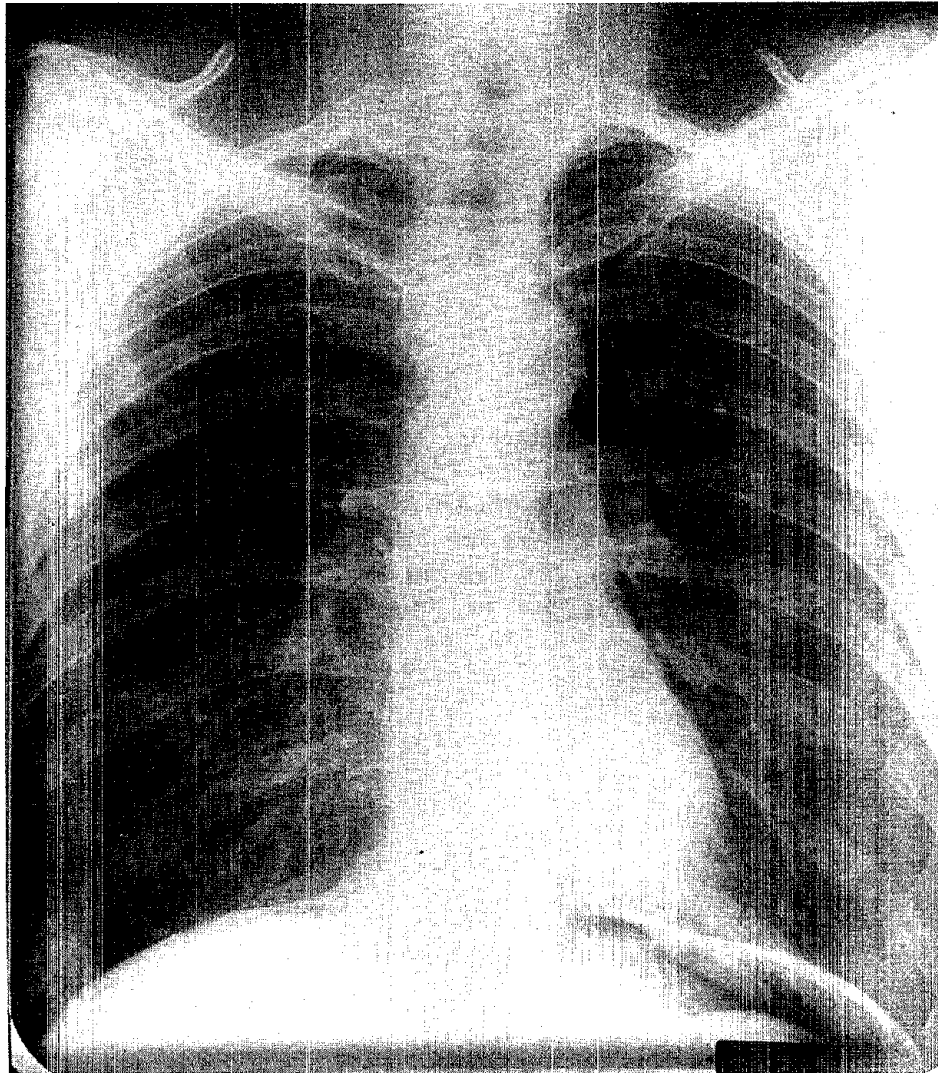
Incorrect position, posteroanterior chest radiograph, with the costophrenic angles cut off.
